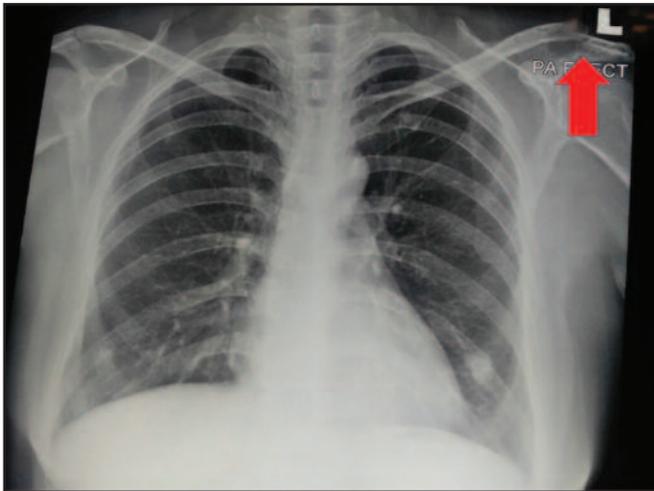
An incidental finding on chest X-ray showing lytic lesion over the left scapula (arrow) which could easily be missed.
